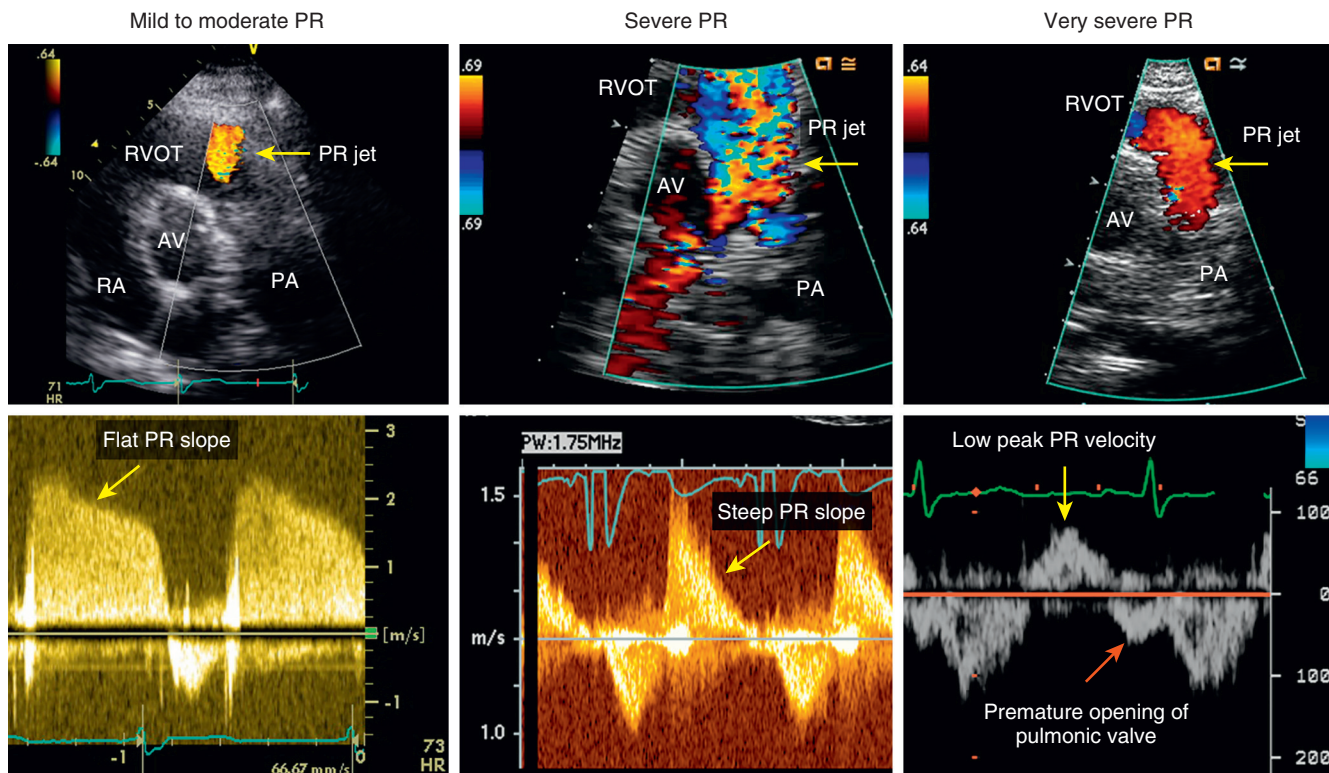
Color and spectral Doppler markers of pulmonic regurgitation. Transthoracic short-axis view at the level of the aortic valve demonstrates color Doppler (top row) and spectral Doppler (bottom row) findings in mild to moderate, severe, and very severe pulmonic regurgitation (PR). Mild to moderate PR: On color Doppler, jet is small (arrow) and vena contracta at jet origin is narrow. On spectral Doppler, the slope of PR jet is relatively flat (arrow). (See accompanying Video 125-1.) Severe PR: On color Doppler, jet is large and turbulent (arrow), whereas on spectral Doppler the PR slope is steep (arrow). (See accompanying Video 125-2.) Very severe PR: On color Doppler, jet is laminar (arrow) and of short duration. On spectral Doppler there is low peak velocity of PR jet (yellow arrow) and there is premature opening of pulmonic valve with abnormal antegrade flow in late diastole. (See accompanying Video 125-3.) AV, Aortic valve; PA, pulmonary artery; RA, right atrium; RVOT, right ventricular outflow tract.
